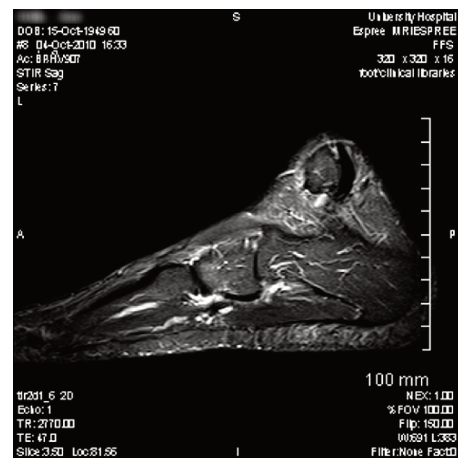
MRI, lateral view at 3 months.
